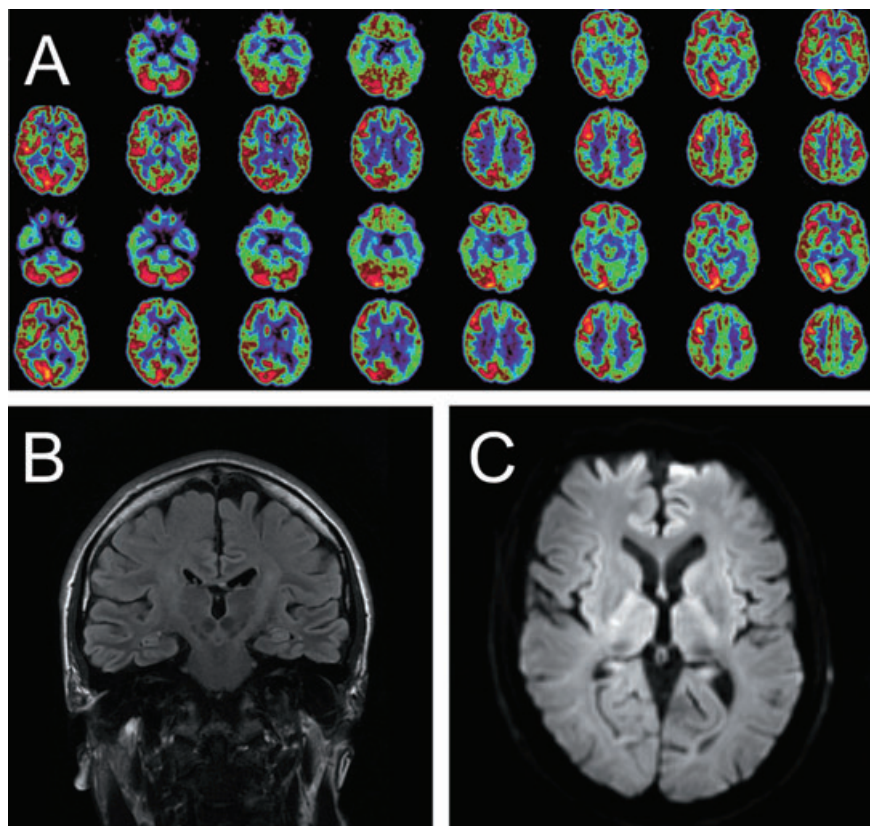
Patient examination by imaging techniques. FDG-PET of the index patient A, demonstrating reduced FDG uptake in the left hemisphere, particularly in the temporal and parietal lobe as well as thalamus and less pronounced in the frontal lobe. B, FLAIR. C, Diffusion-weighted MRI images showed hyperintense lesions in the cortical ribbon and thalamus.
